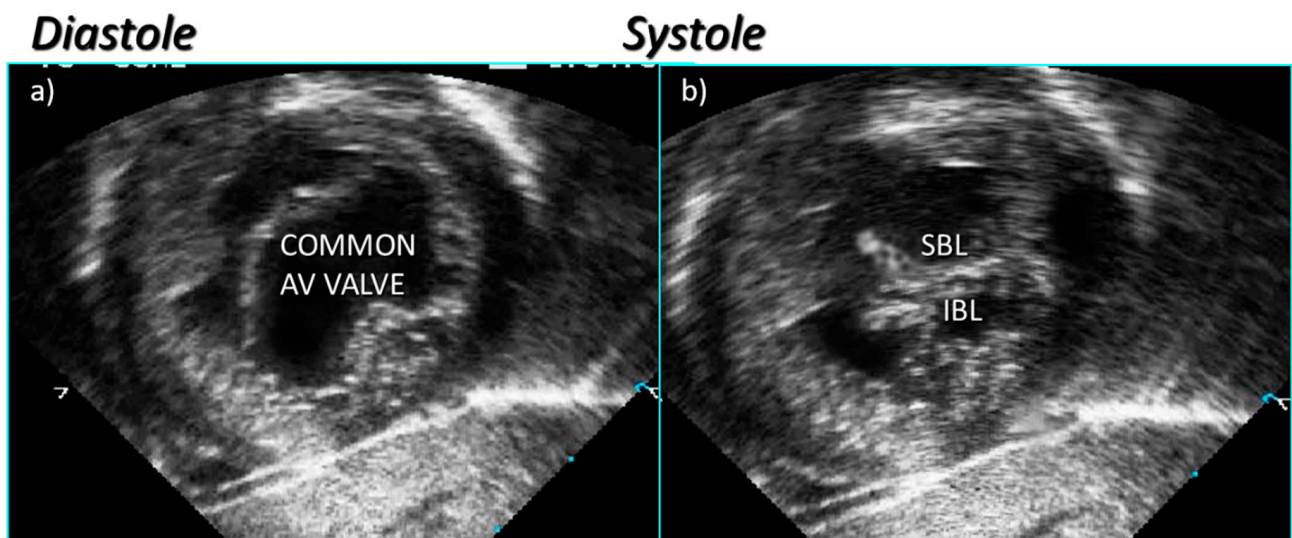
Subcostal left oblique short axis echocardiographic section of AV junction at level of AV valve leaflets showing (a) common atrioventricular valve during atrial systole and (b) the zone of apposition of the superior and inferior bridging leaflets.
